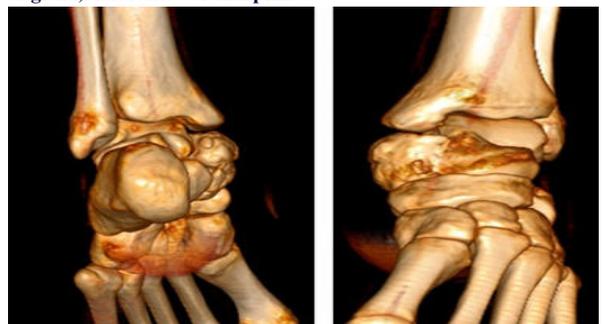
Plain CT of the Left Ankle with 3D Reconstruction in Sagittal, Axial and Coronal planes.
